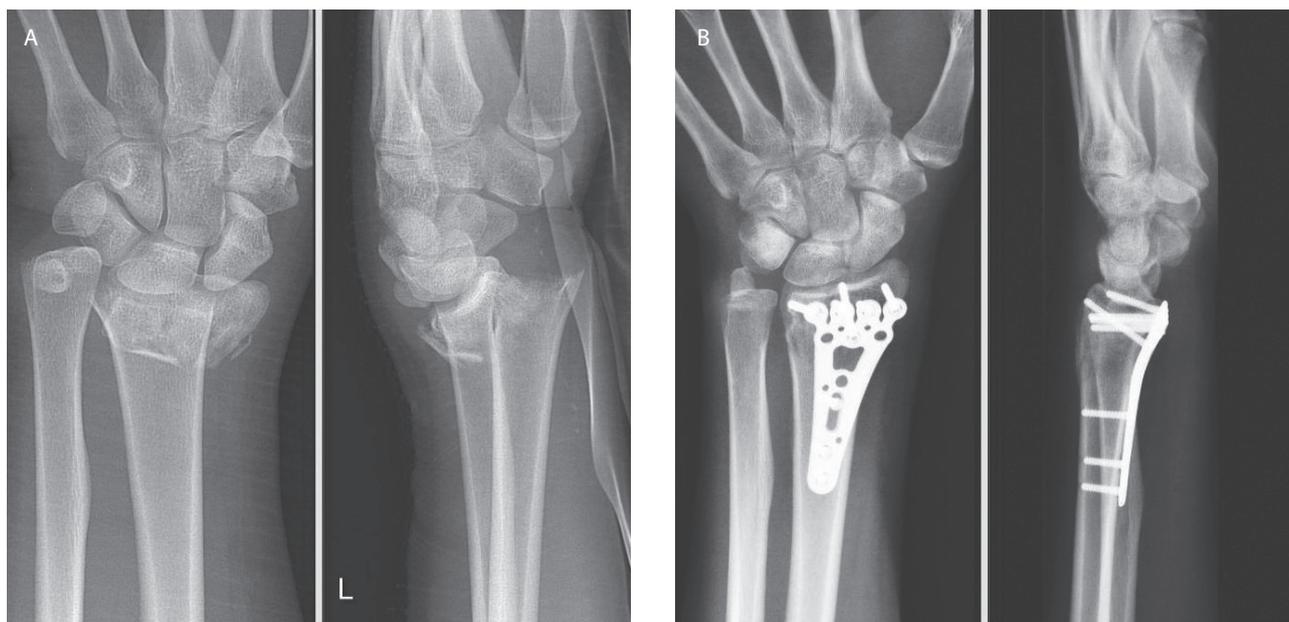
A type C1 fracture of the distal radius. Postero-anterior and lateral radiographs of the fracture (patient V.H.) A) after injury; B) at 3 months after Aptus radius locking plate fixation.
